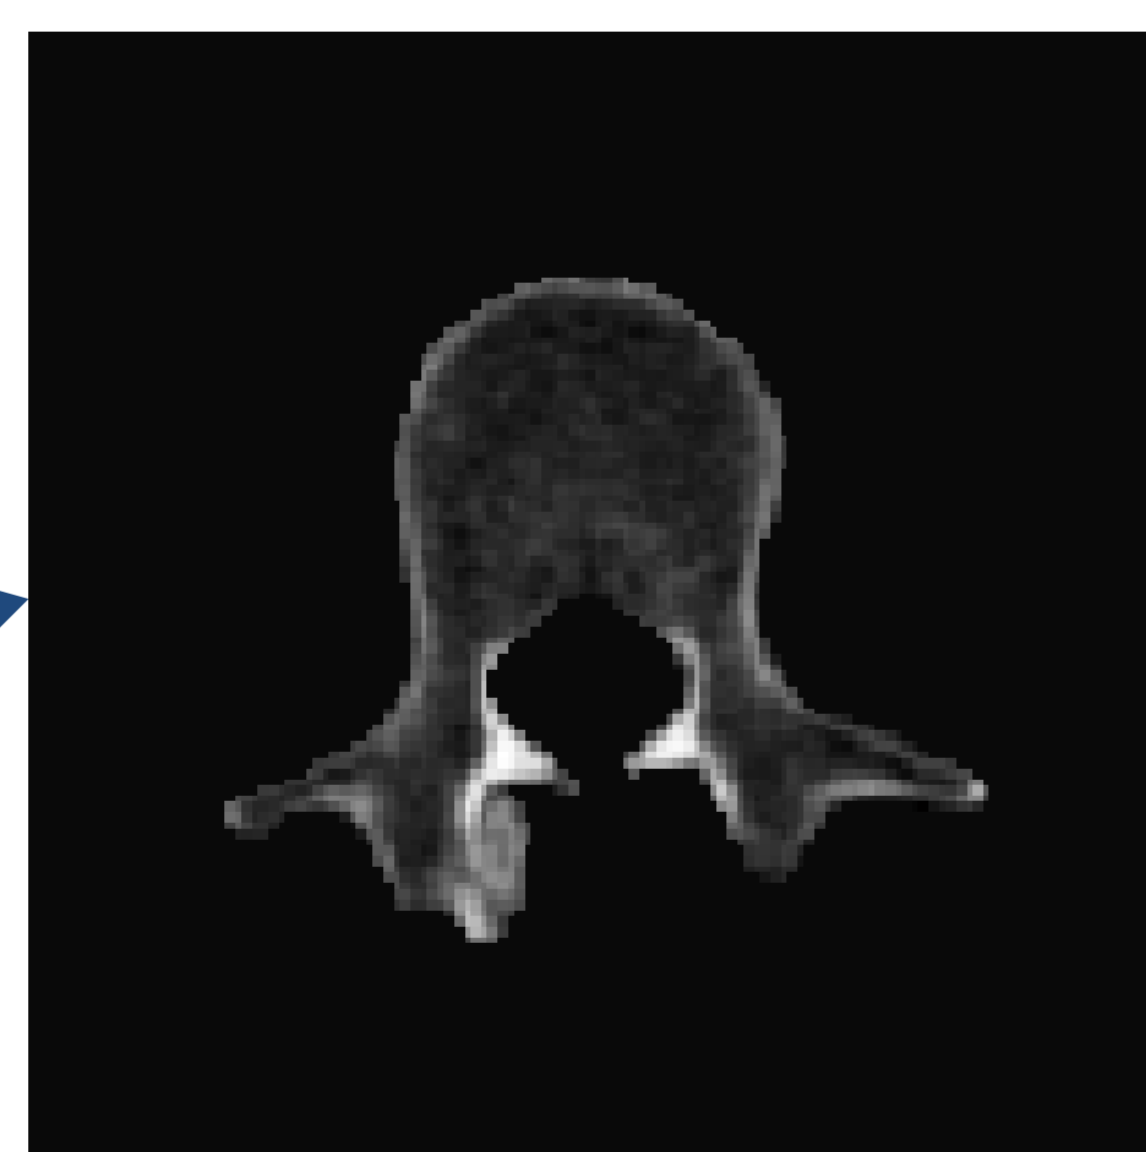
Vertebral segmentation from a single CT image. From vertebral segmentation, three-dimensional model of the spine is constructed.
